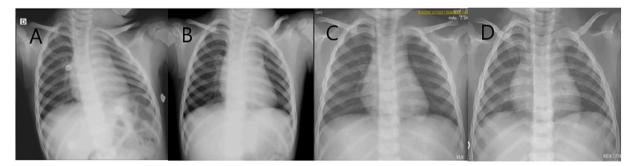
Serial X-ray during hospital stay showing spontaneous pneumothorax regression, without the need of surgical procedures. (A) 03/09, (B) 04/09, (C) 05/09, (D) 07/09.
